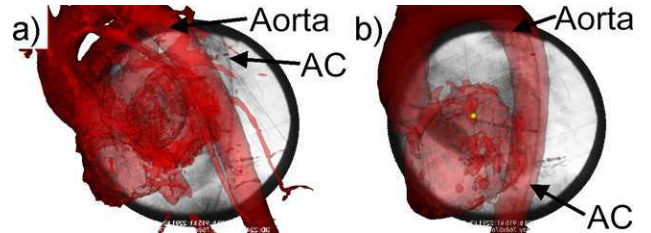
a) Model of the heart (*red*) overlaid on the X-ray using only the CS to constrain the registration, but is misaligned. b) Both the CS and aortic catheter/vessel pairs are used, resulting in a more accurate registration.
